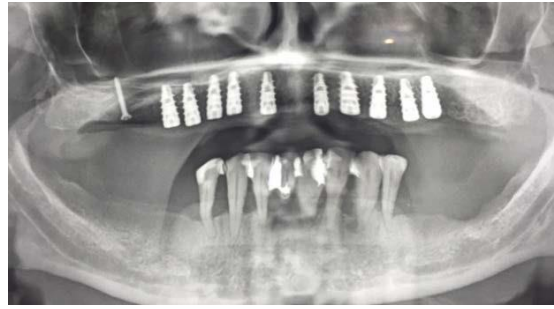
Rx-Orthopantomogram postoperative with multi-implants inserted in graft.*
